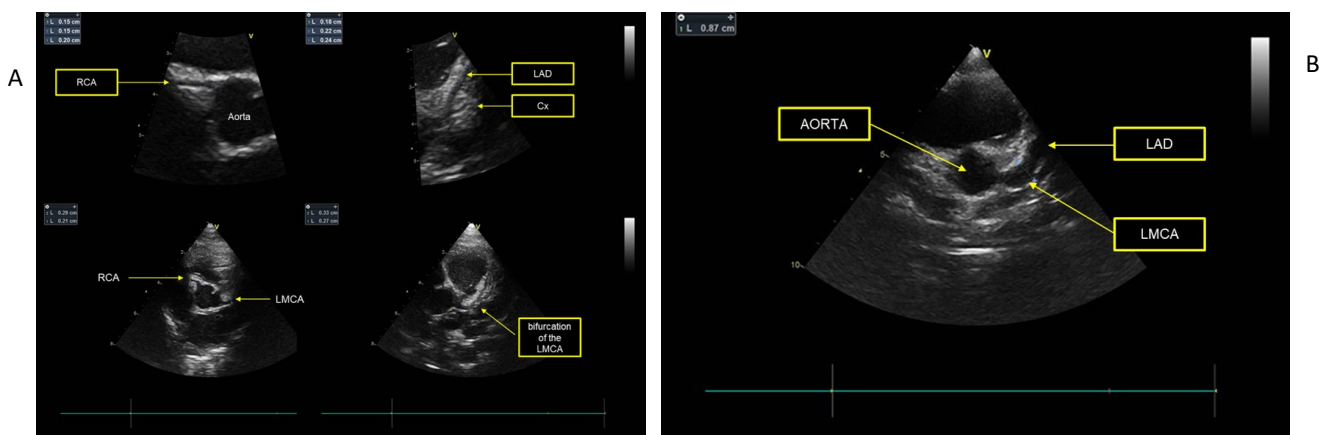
Coronary arteries in two-dimensional transthoracic echocardiography (The left parasternal position, a modified parasternal short axis view of great vessels) :
